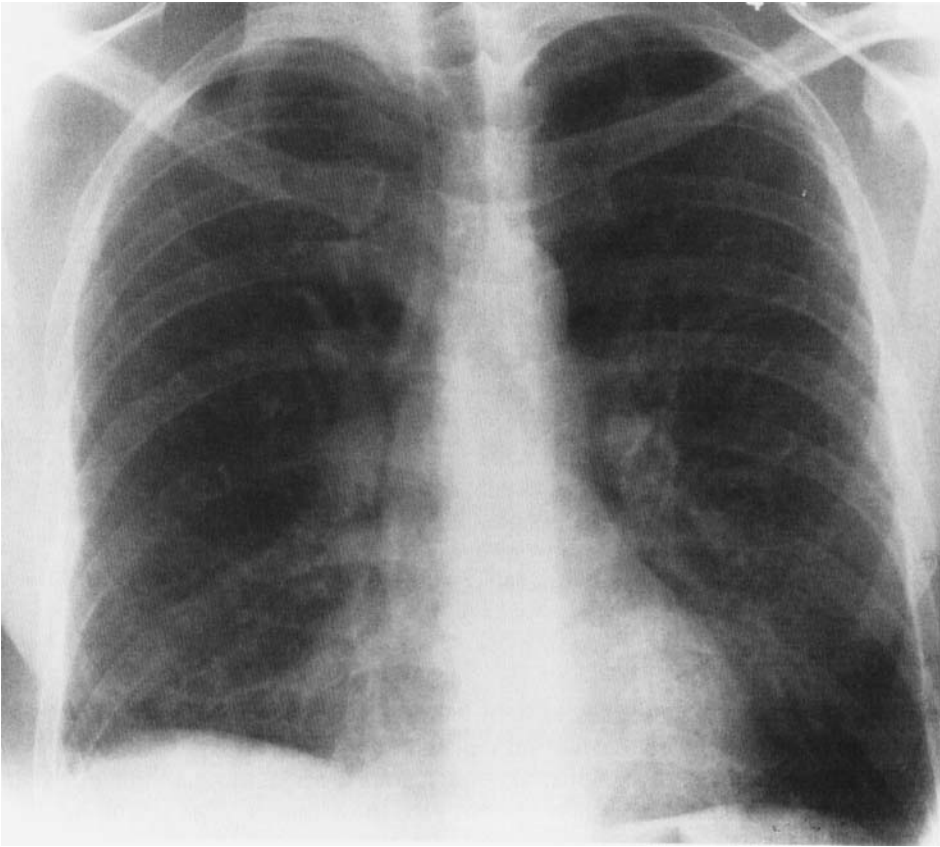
Chest radiograph obtained on admission of the patient with CGD, showing a fine reticular infiltrate most prominent at the base.
